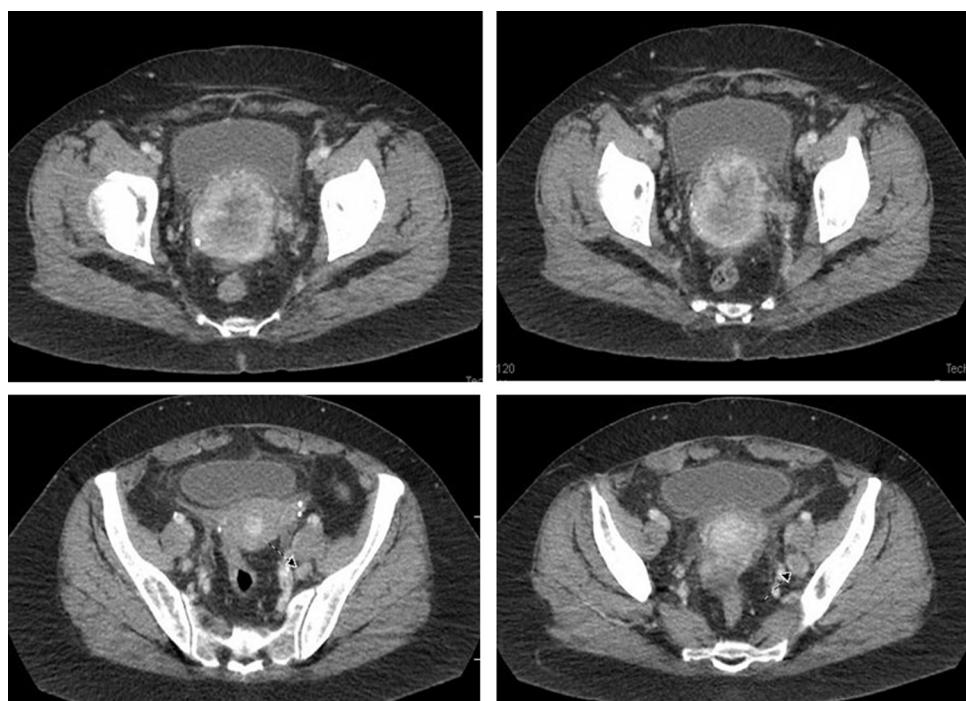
The patient's pretreatment computed tomography (CT) scan. The top two images show the primary cervical mass. The bottom two images demonstrate the left external iliac lymphadenopathy.
